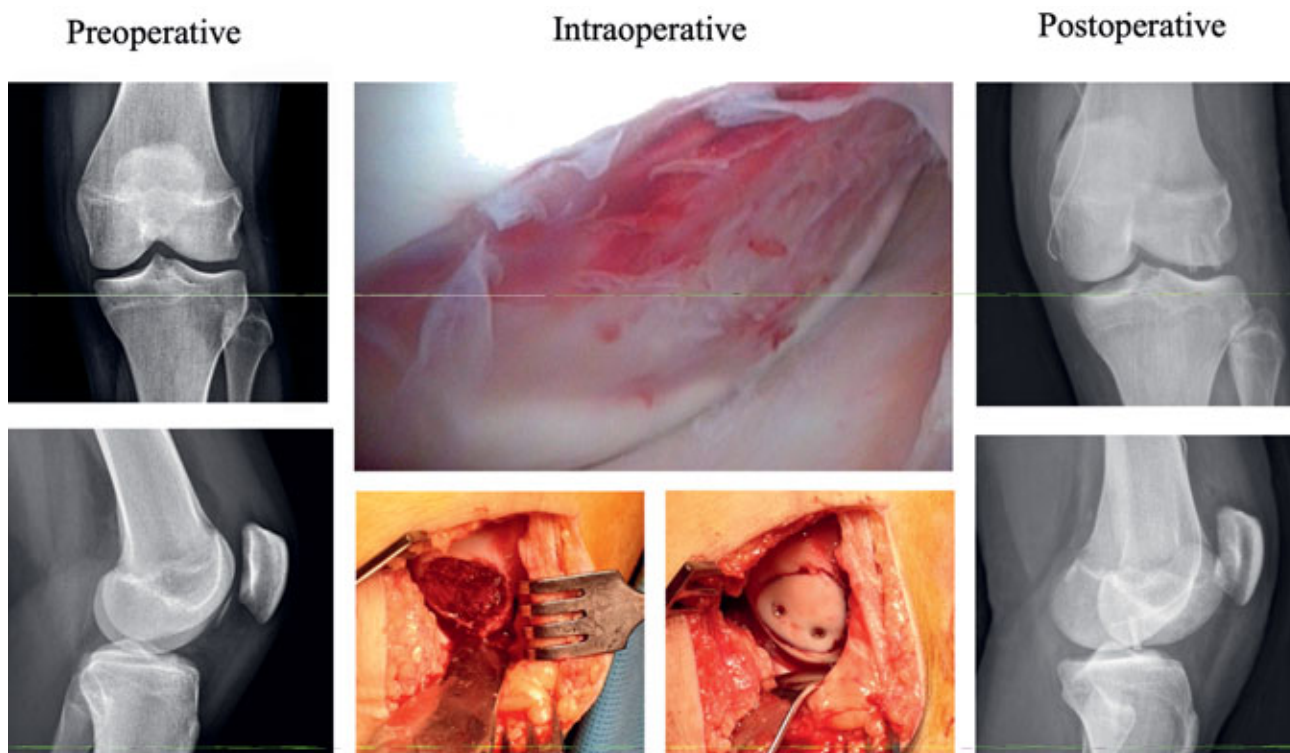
Lateral condyle osteochondral fracture in a 13-year-old girl after an episode of patellar dislocation. Preoperative X-rays showing dislocated osteochondral lesion; intraoperative – arthroscopic evaluation of lesion, fixation with 2 MAGNEZIX screws Ø2.7 mm/16, 16 mm from lateral arthrotomy; postoperative X-rays confirm fracture reduction and show position of the implants. (Patient 1).
